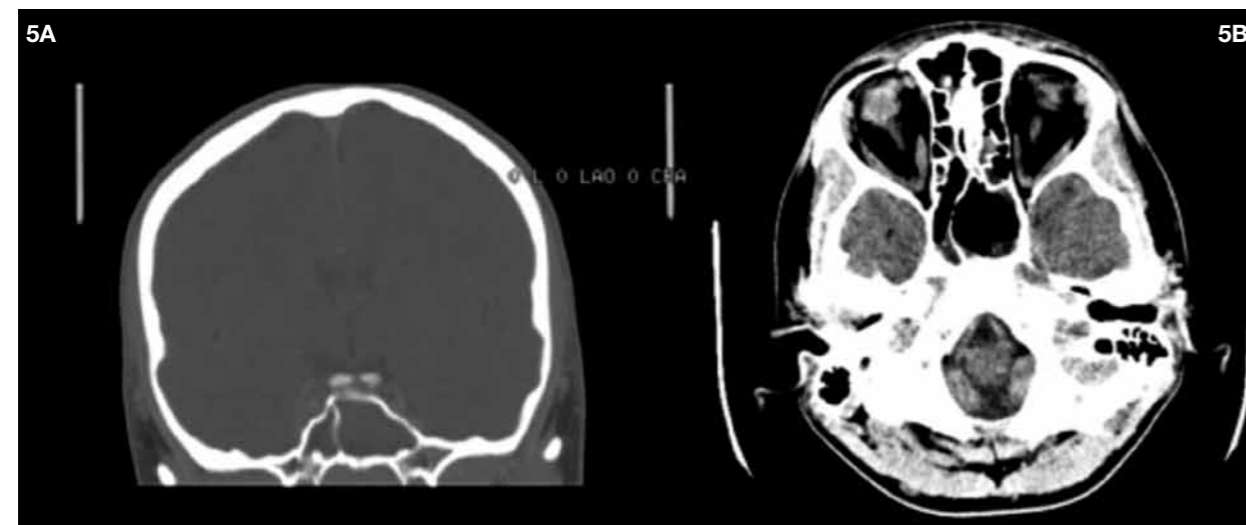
Case 1: 5A) Coronal CT scan showing opacified sphenoids with right cavernous sinus enlargement, relatively low peripheral enhancement outlines a large low density filling defect consistent with thrombus. The right superior ophthalmic vein was also noted to be dilated with no thrombus in this series. 5B) Axial CT scan day 5 following surgical drainage with reduction of fluid in the sphenoid sinuses.
